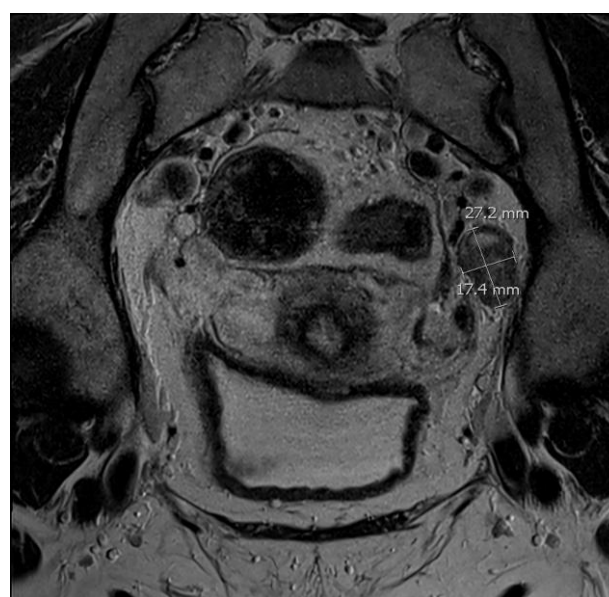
Left external iliac/ obturator lymph node (coronal view, MRI) mass.
